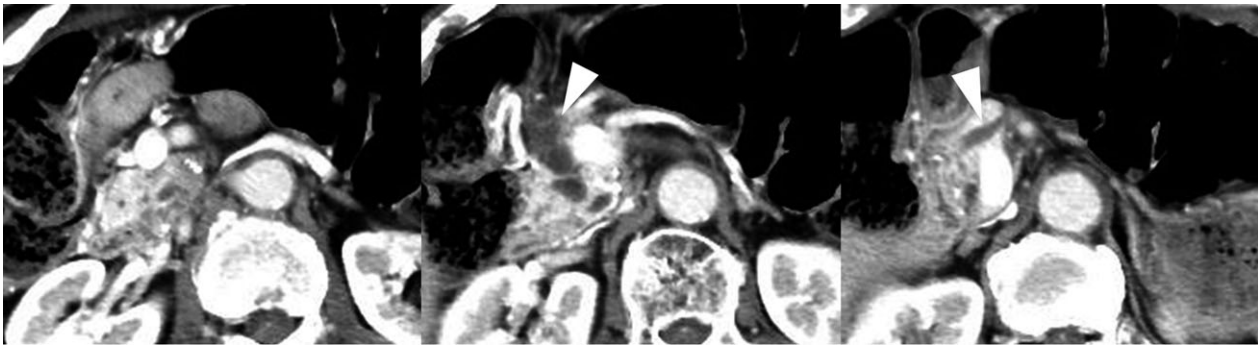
Computed tomography of the remnant pancreas of a patient with an intraductal papillary mucinous neoplasm and concomitant pancreatic adenocarcinoma, showing a dilated pancreatic duct (arrowheads) but no apparent solid tumor in the remnant pancreas.
